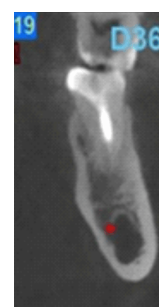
CBCT in coronal view of distal root of tooth 36 revealing an apical healing in progress (one-year follow-up).
